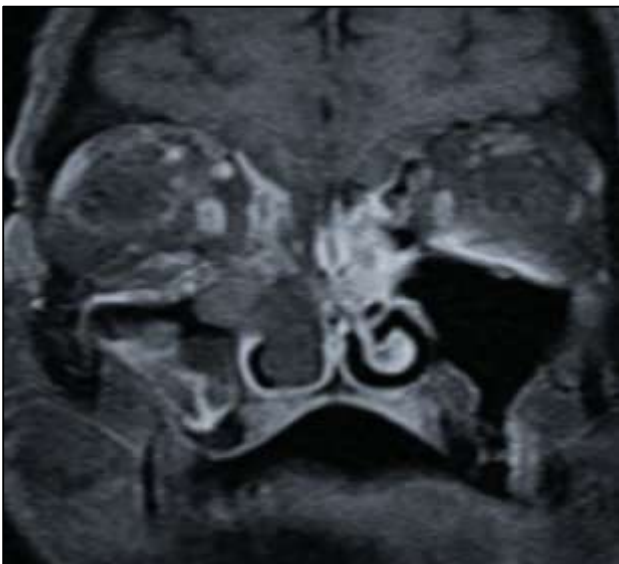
Contrast enhanced fat saturated T1 weighted MRI showing peripheral and central enhancement of enlarged right inferior turbinate (Black turbinate).
